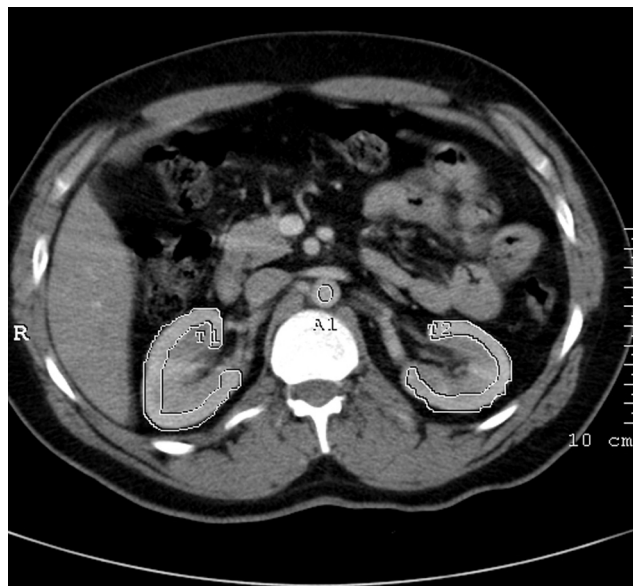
Axial perfusion CT image shows ROIs around the renal cortex.
